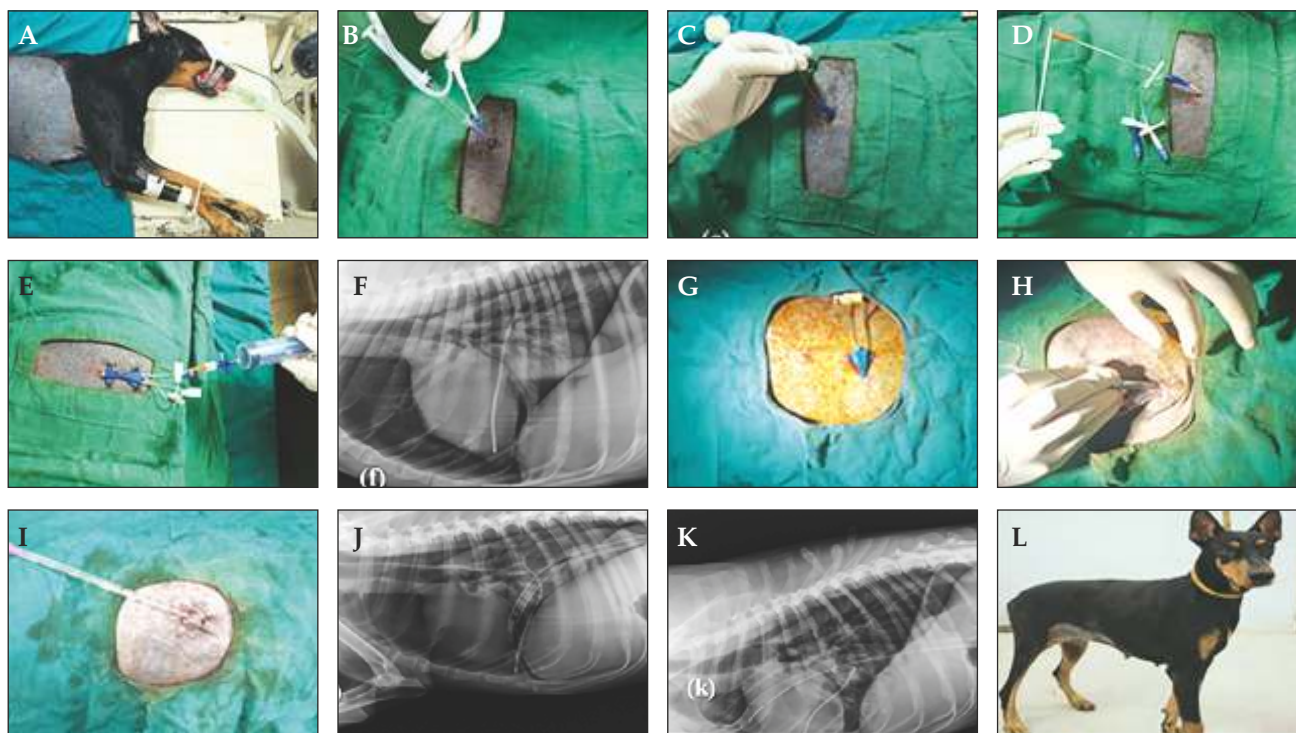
(A) Induction, intubation and site preparation for 7FG CVC placement (Seldinger Technique); (B) Percutaneous puncture of 7th ICS; (C) Insertion of 'J'-tipped guidewire; (D) Placement and fixation of CVC; (E) Aspiration of air from pleural space; (F) Post-CVC radiograph showing mild pneumothorax improvement; (G) Aseptic preparation of thoracic wall; (H) Subcutaneous tunnelling for 32 FG TDC insertion; (I) TDC secured using Chinese finger trap technique; (J) Post-placement radiograph showing effective pleural air evacuation; (K) Day 1 radiograph showing TDC in situ with pneumothorax resolved; (L) 45-day follow-up showing complete clinical recovery.
